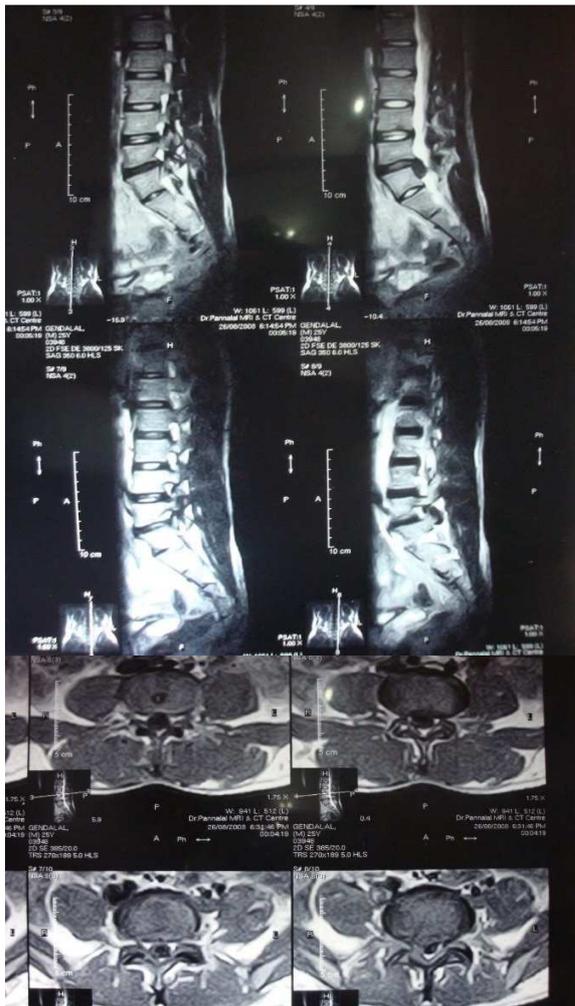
MRI impression – annular disc bulge at L5-S1 level with right paracentral extrusion and caudal migration at L5-S1 level indenting the thecal sac and the nerve roots bilaterally, more on the right side.
